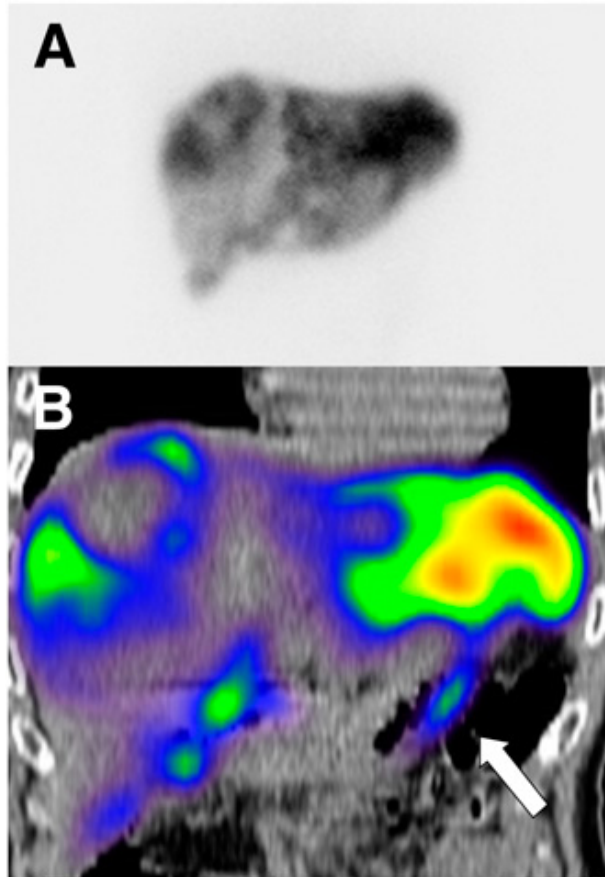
Duodenal accumulation (arrow) in a patient with colorectal cancer, not definable on planar images. A: planar scan, B:SPECT/CT coronal view (60)
